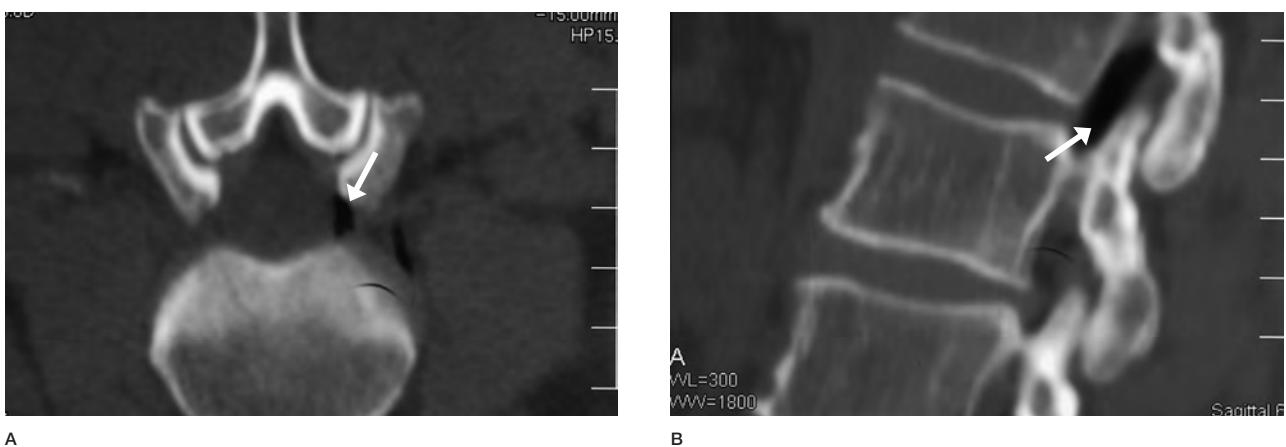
A) CT axial scan showing the presence of gas in the foraminal region after O₂-O₃ treatment (arrows). B) CT sagittal reconstruction confirming the gas mixture in the left L2-L3 root canal (arrows)
